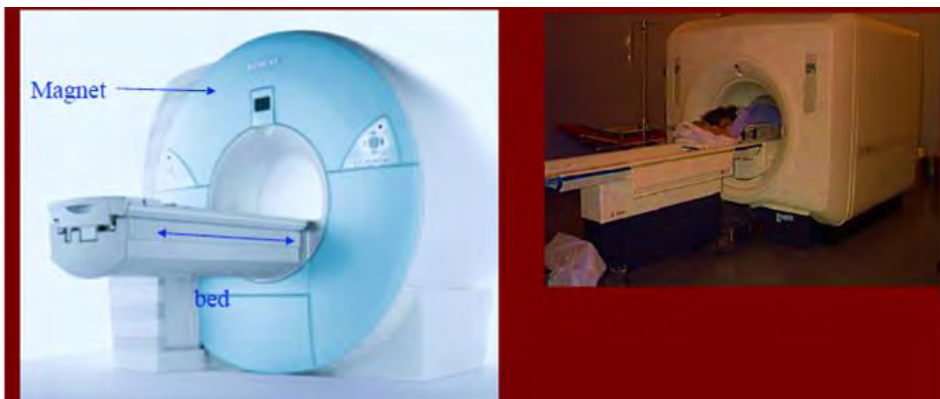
Siemens Avanto 1.5T state-of-the art MRI machine [Curtsey of “Basics of MRI Professor” Sir Michael Brady FRS FREng Department of Engineering Science Oxford University Michaelmas 2004 PP.7.]
